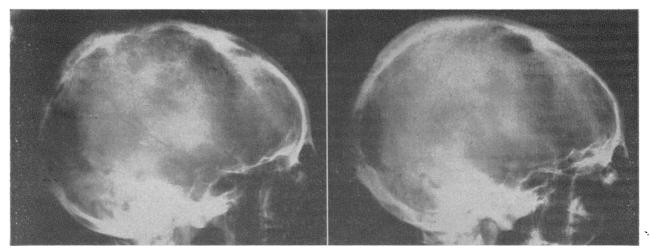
Case 2. Recalcification of Hodgkin's deposits in the skull after treatment with cyclophosphamide. Radiographs taken in February and July, 1960.
